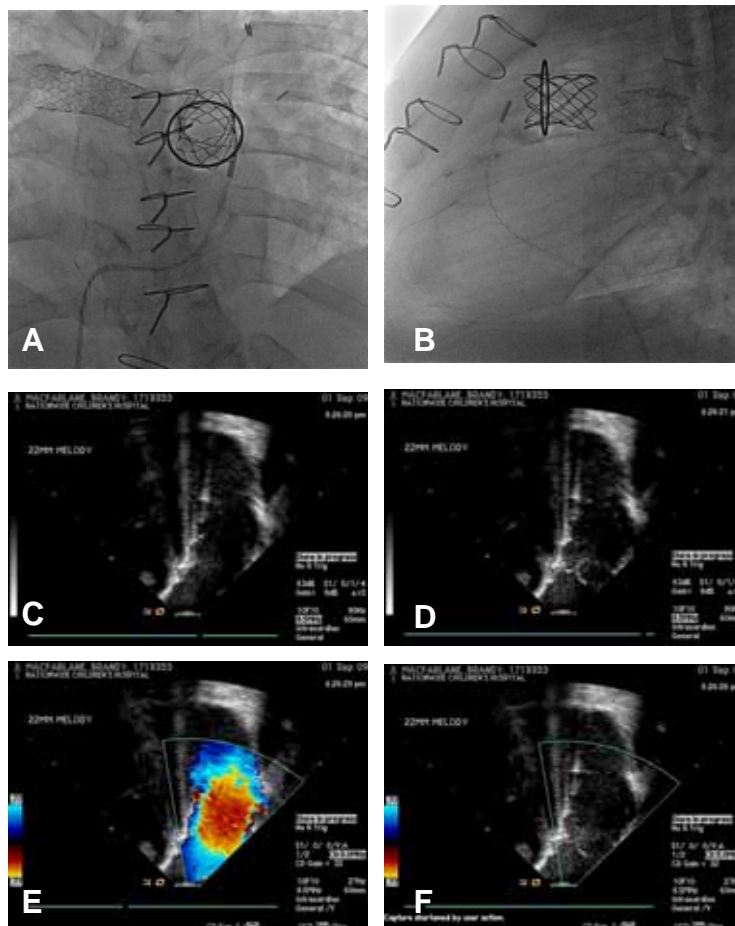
(A&B) Shows placement of the ICE catheter in the RVOT beneath the Melody TPV. ICE imaging shows the valve in the open (C) and closed (D) position with coaptation of the valve leaflets. Color flow Doppler in the open (E) and closed (F) position shows no significant pulmonary regurgitation and a mean gradient of 4-5mmHg.
